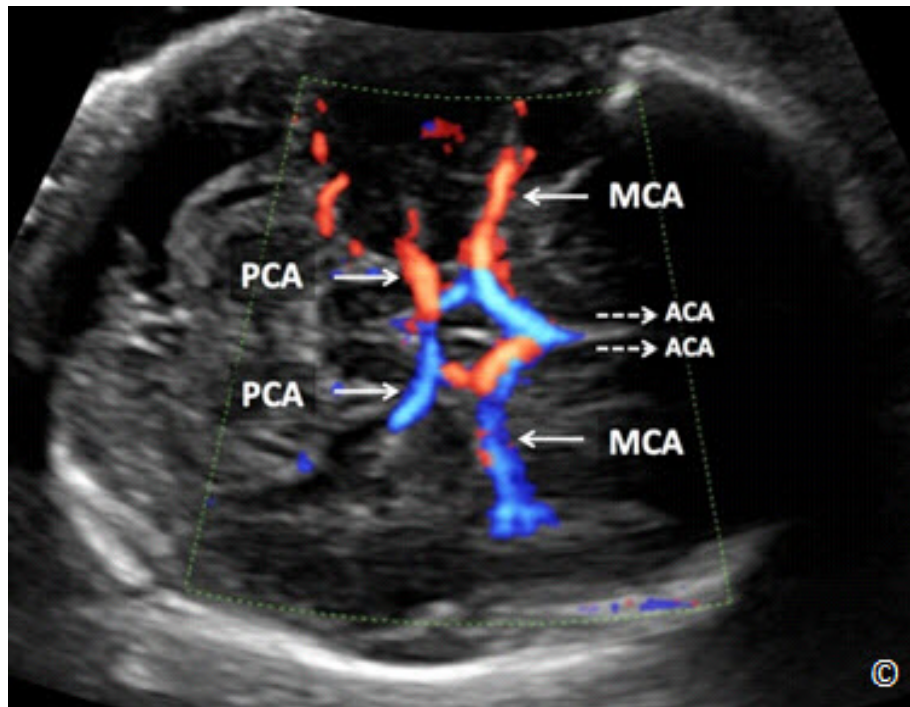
Transverse plane at the base of the fetal brain with color Doppler mode showing the circle of Willis. Note the course of the middle cerebral arteries (MCA) and posterior cerebral arteries (PCA). The anterior cerebral arteries (ACA) are not seen due to their course perpendicular to the ultrasound beam (dashed arrows).
